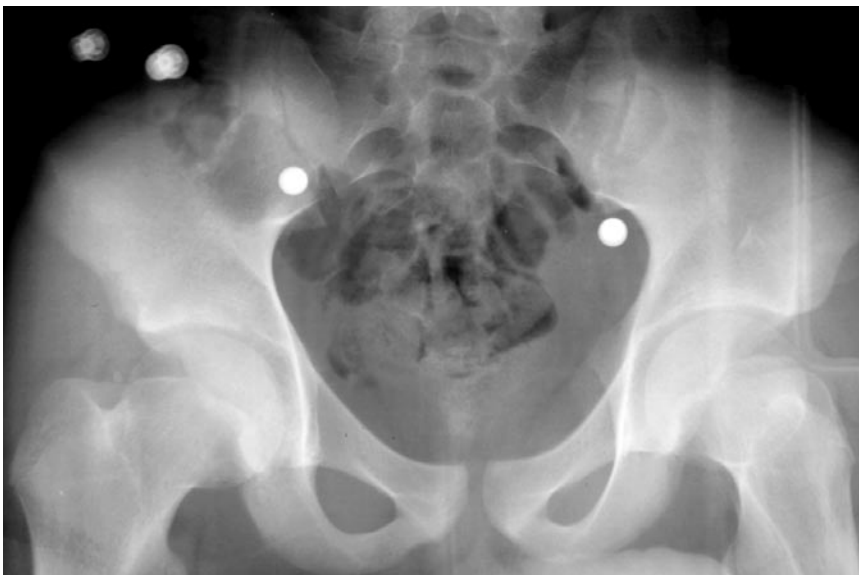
Anteroposterior pelvis x-ray taken at time of patient's original injury (age 16 years 0 month) shows no femoral neck fracture or osteonecrosis of left hip.
